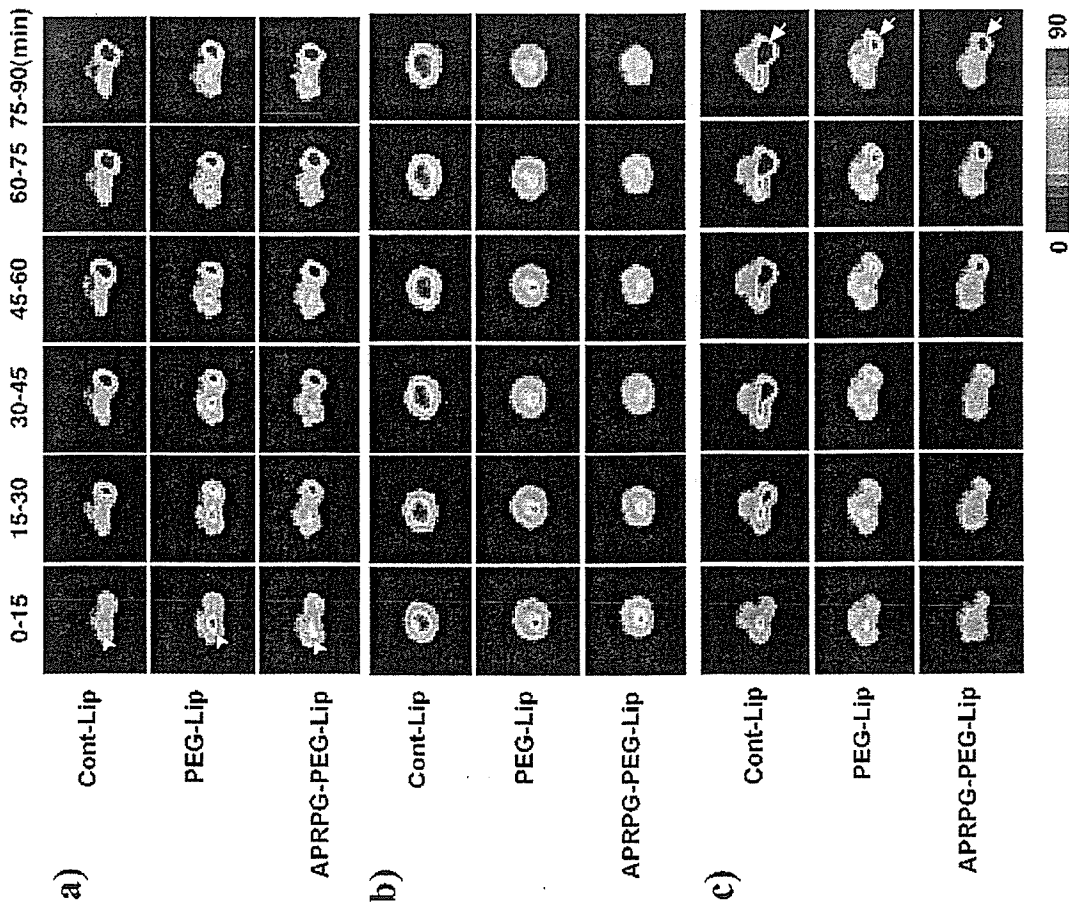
PET Images of $[2-^{18}\text{F}]\text{FDG}$ -Labeled Liposomal Distribution
